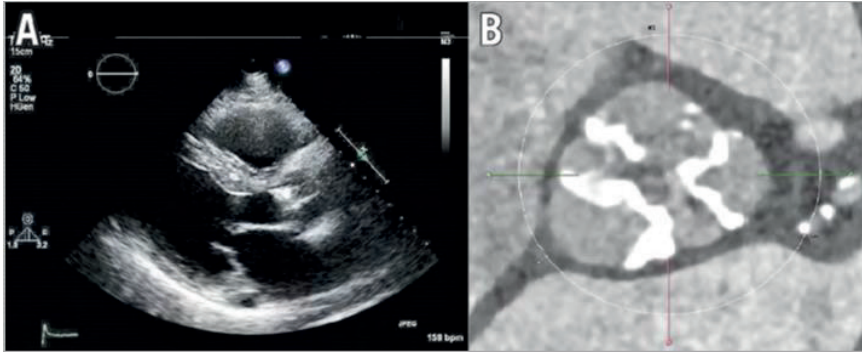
Imaging during work-up. A) Transthoracic echocardiography showing a severely calcified aortic valve. B) Severely calcified aortic valve on multislice computed tomography.
